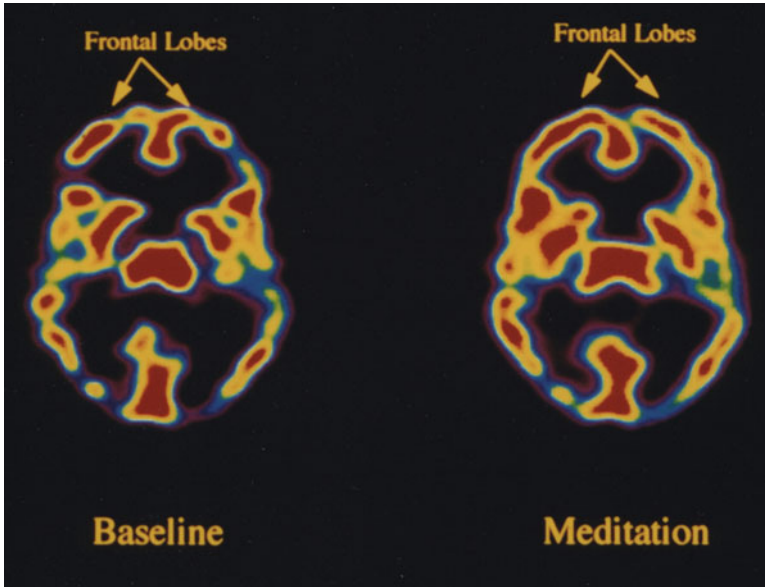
SPECT scan during meditation showing increased cerebral blood flow in the frontal lobe areas during meditation
